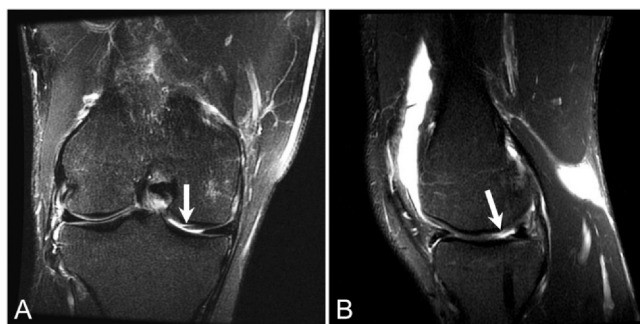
Elite baseball player presents with right posteromedial knee soreness. Coronal T2 FS (A) and sagittal T2 FS (B) MR images show a delaminating high-grade partial-thickness chondral flap at the central weightbearing aspect of the medial femoral condyle, an unstable lesion. FS, fat saturation; MR, magnetic resonance.
